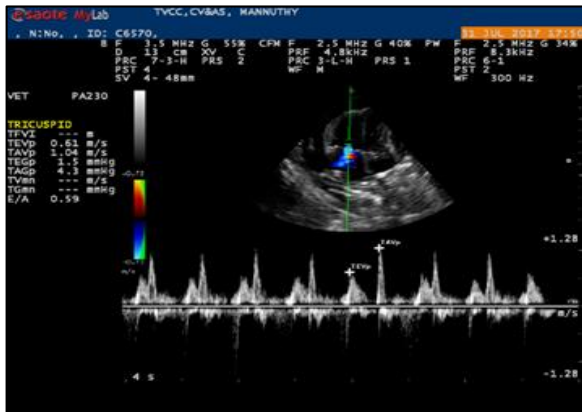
Pulsed wave Doppler at tricuspid valve level (A>E-Diastolic dysfunction)
